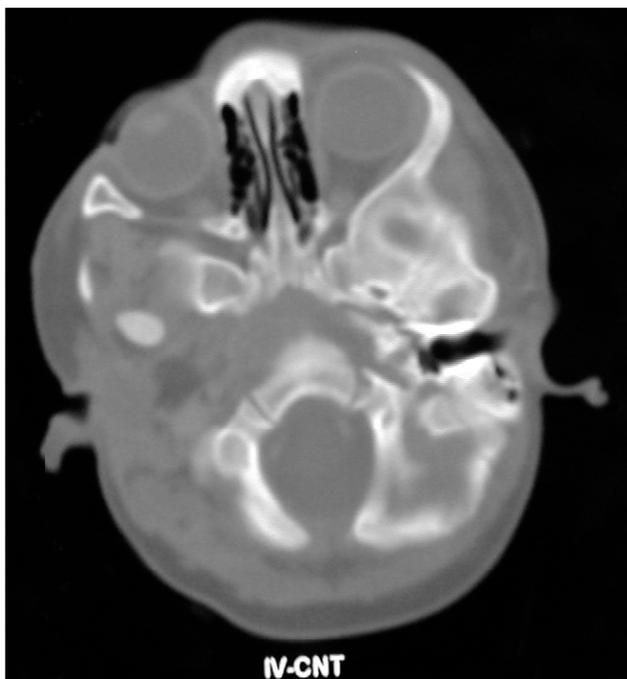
On cranial computed tomography with intravenous 1 administration of contrast substance, right occipitoparietal and one occipital subcutaneous masses were seen without any bone destruction and hyperostosis.
